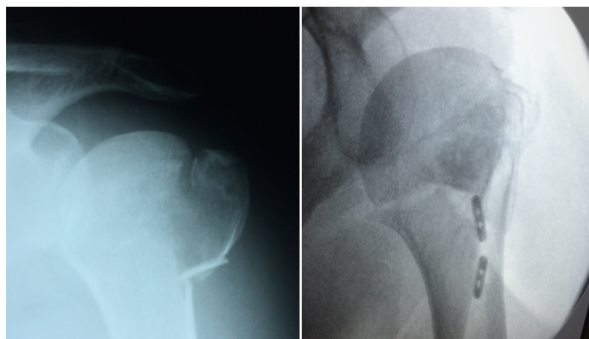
A. Two parts fracture: radiography; B. Radiographic post operative evaluation.
